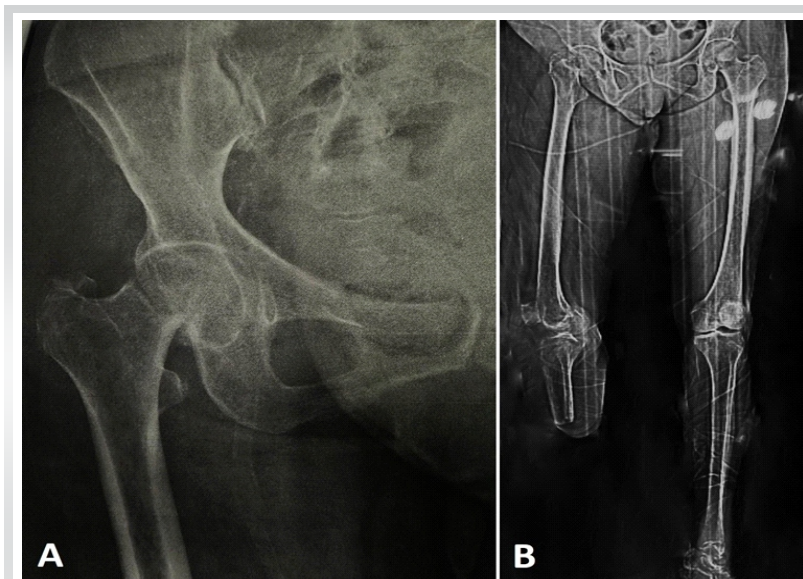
(a) Pre-operative radiograph of the right hip showing a fracture in the neck of the femur, (b) full-length scanogram of both the lower limbs.
